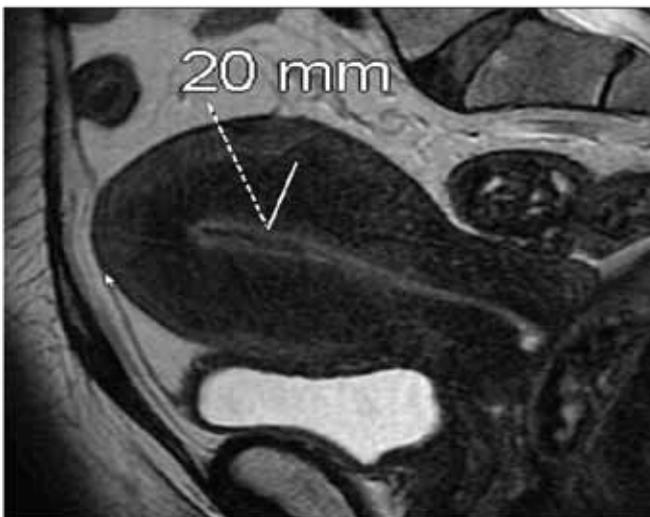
Sagittal T2-weighted MR image of a uterus with adenomyosis, indicated by junctional zone thickening greater than 12 mm (T2- and T1-hyperintense foci of myometrial glandular tissue support the diagnosis, not depicted here).
